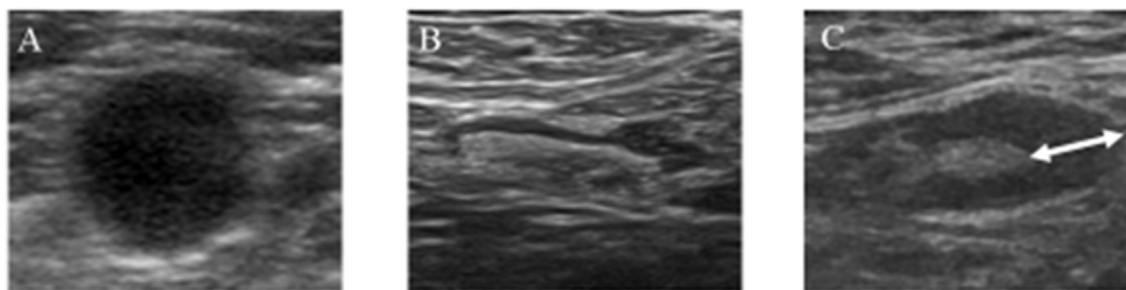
The shape of the lymph nodes on ultrasound sonography. A lymph node with the absence of a fatty hilum (A), a lymph node with focal cortical thickness (B), the cortical thickness of the lymph node (C).
